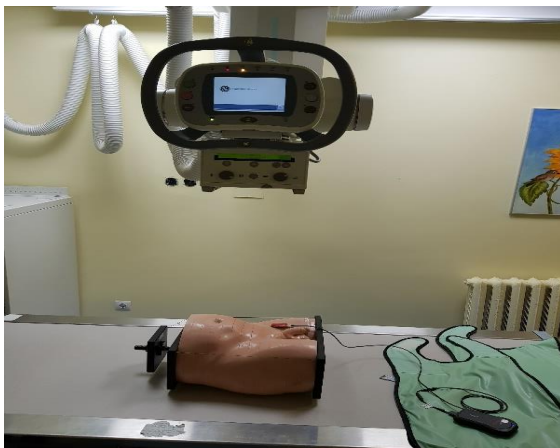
Images were obtained from three digital X-ray equipment (General Electronics, Siemens and Shimatzu) at Vilnius University Hospital Santaros Klinikos, (table 1). Medical physicists of hospital perform regular quality control and assurance testing of X-ray equipments in accordance with the radiation protection act of the Republic of Lithuania [6].
